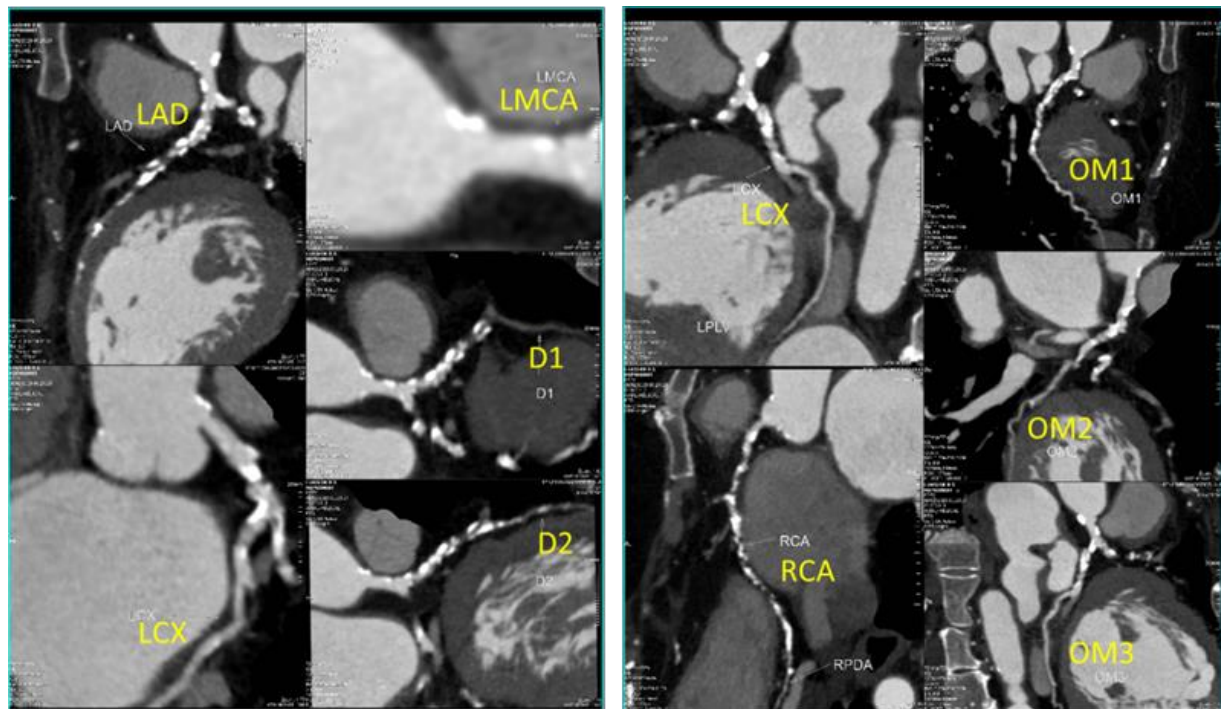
CT-CAG with the Calcium Score calculated as 2737 whereas, Diagnosis Impression reported by radiologists is the Occlusion of mid LAD with 70-80% stenosis of distal RCA, 60-70% stenosis of distal LAD, 30-40% stenosis of LCX and 40-50% stenosis on proximal RCA.
